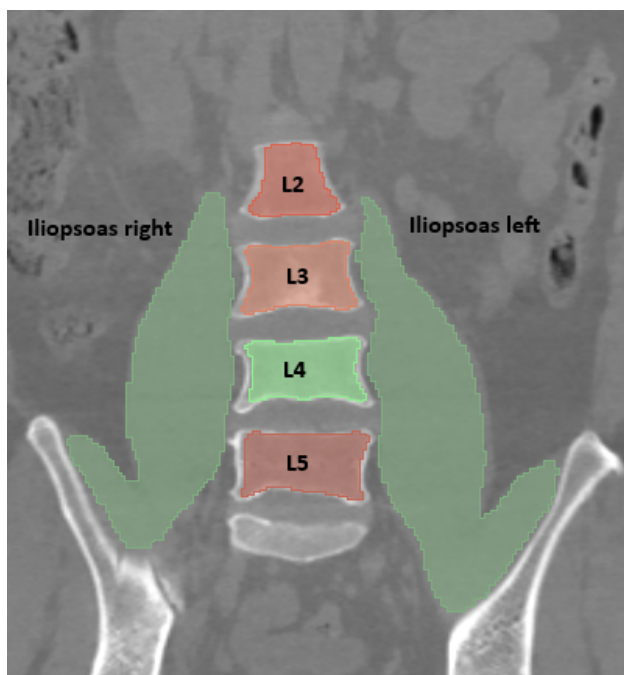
Anatomical position of the psoas major muscle (in green) in relation to the lumbar vertebrae and pelvis as seen on a coronal CT scan.
